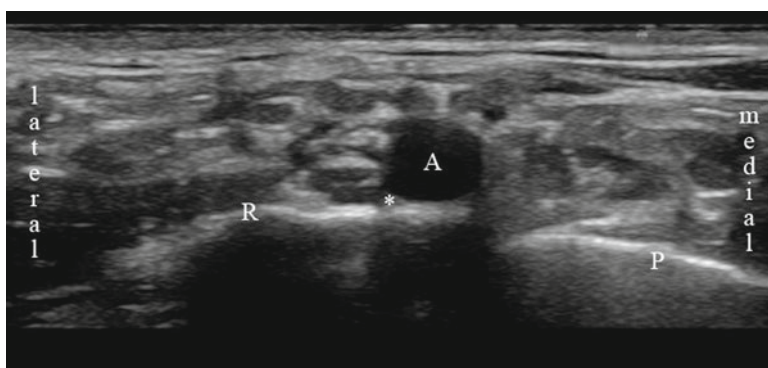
Ultrasonographic appearance of the supraclavicular brachial plexus (A subclavian artery, P pleura, R first rib, asterisk indicates target)
